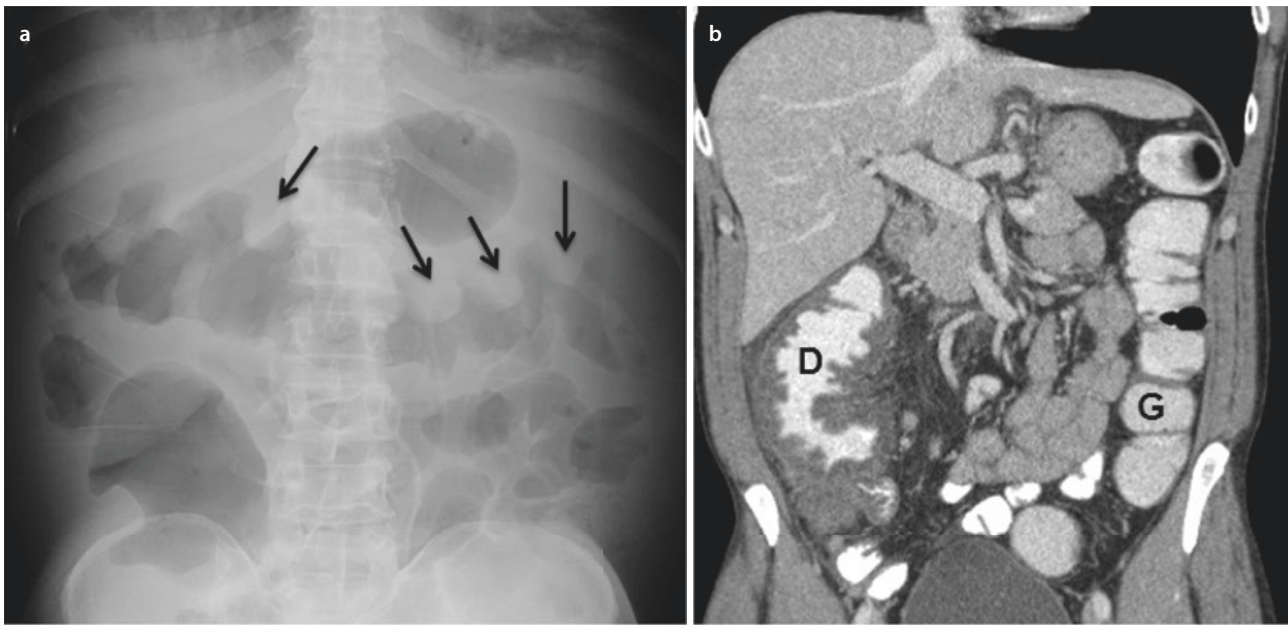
Colitis images: a flat plate of the abdomen showing parietal edema of the transverse colon with thumbprint images (indicated by the arrows); b CT scan with significant wall thickening of the right colon (D), while the left colon (L) is normal. (Photos from R. Déry)
